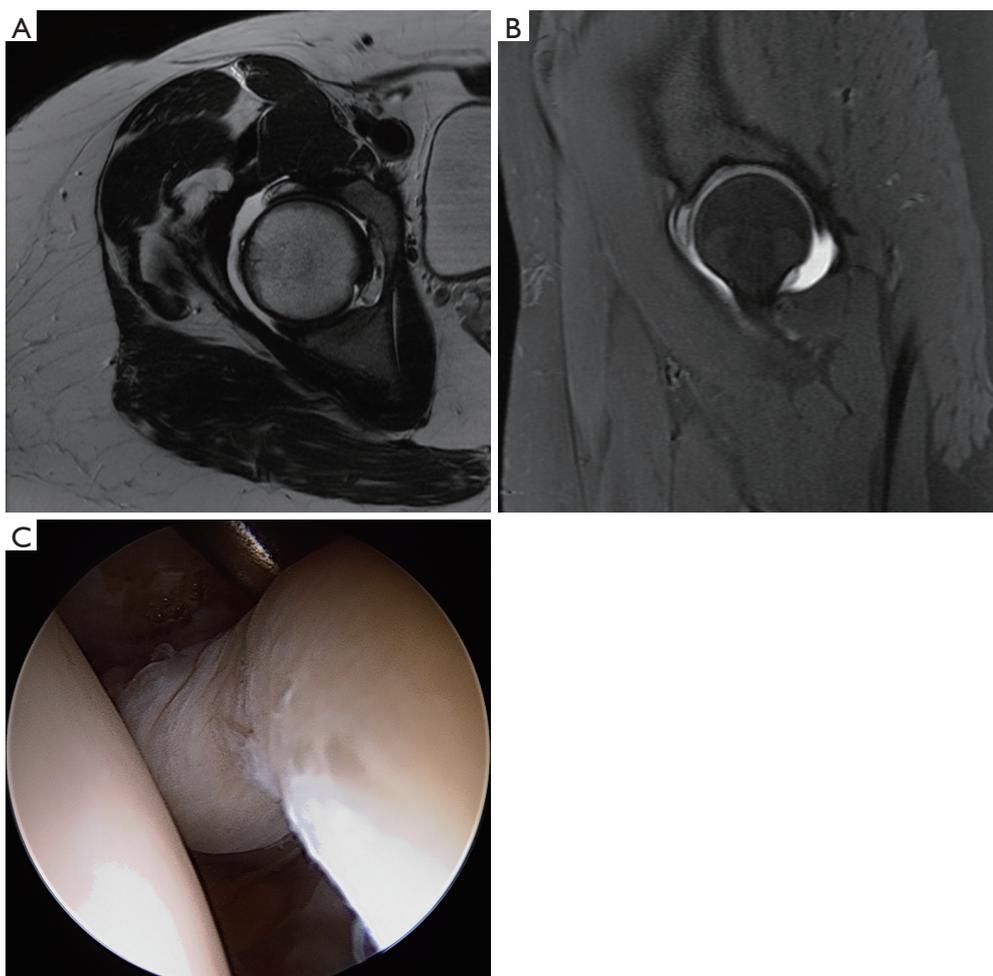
Obtaining excellent central compartment visualization is necessary to perform a proper labral repair. Large hypertrophic labra may preclude easy comprehensive visualization. (A) Right hip T1-weighted axial MRI with arthrogram of a 22-year-old female with Ehlers-Danlos syndrome demonstrating a large hypertrophic globular labrum; (B) same patient with a T2-weighted sagittal MRI with redemonstration of large hypertrophic globular labrum; (C) left hip arthroscopy, viewing from AL portal, of 31-year-old non-dysplastic female with generalized joint hypermobility (8/9 Beighton) demonstrating large hypertrophic labrum. MRI, magnetic resonance imaging; AL, anterolateral.
